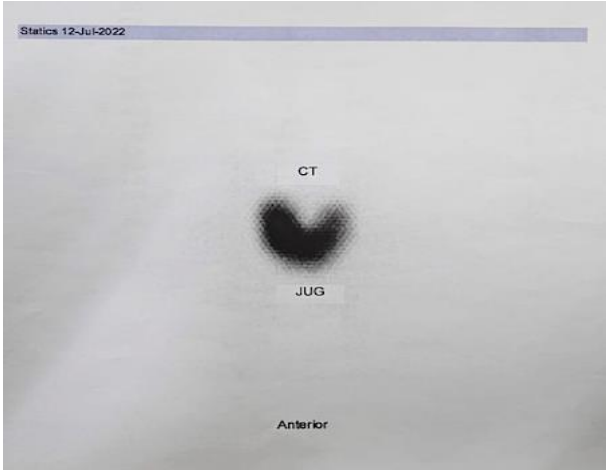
Thyroid scintigraphy on July 12, 2022, at Dr. Soetomo HospitalThe thyroid function test was held in two different institutions. It is shown in Table 1 at Biotest Clinic Surabaya and Table 2 at Dr. Soetomo Hospital
